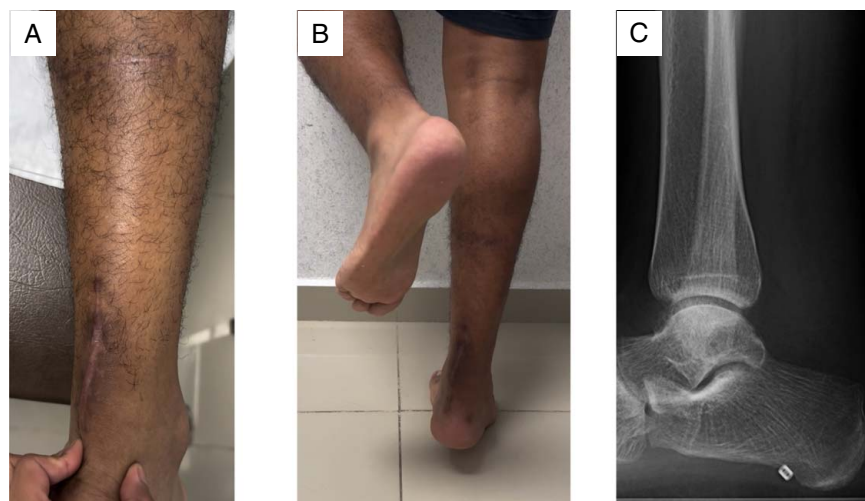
(A) Scars without complications. Adequate tendon continuity and consistency. (B) Single heel rise at 16 weeks postoperatively. (C) Adequate button position in radiographic control.
